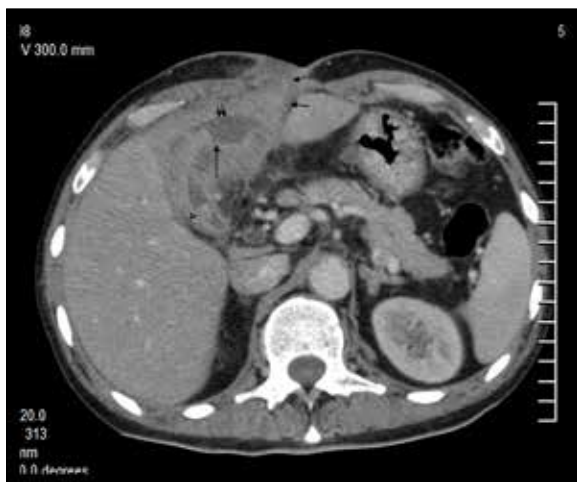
Contrast-enhanced axial CT showing a heterogeneously-enhancing thickened GB wall with small peri-cholecystic fluid collection (double arrow) adjacent to a small defect in the GB wall (long vertical arrow). Linear fistula tract is seen extending from the GB fossa to skin (small arrows). Hyperdense calculus is also noted in the lumen of GB (arrow head).
